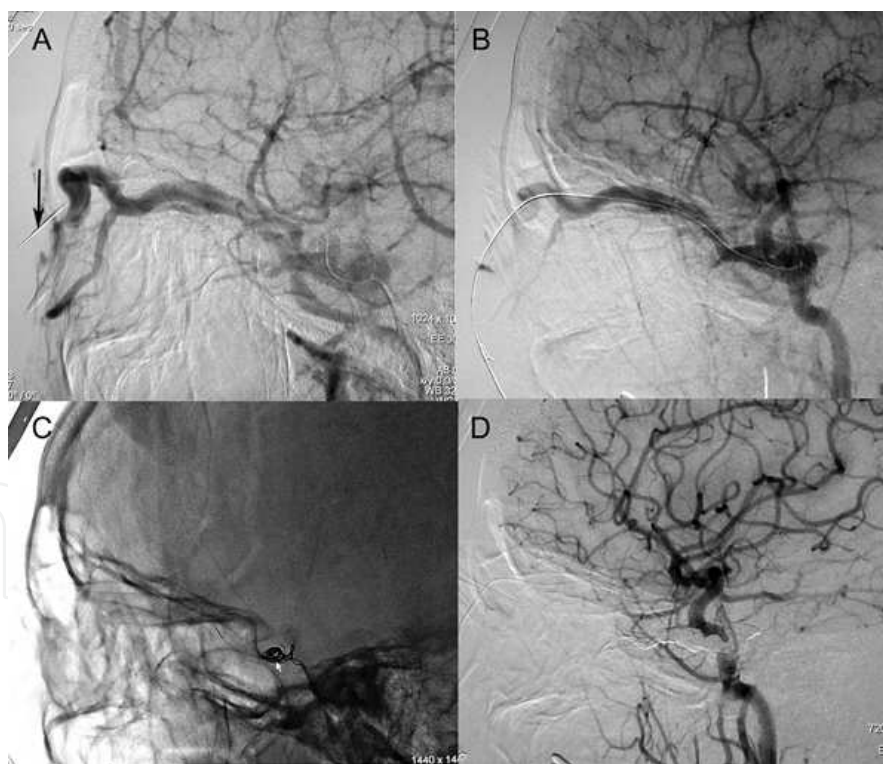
Right CCA angiogram, frontal projection (A), showing a DAVF involving the right CS fed by the left meningo-hypophyseal trunk and the right internal maxillary artery. Venous phase of the right CCA (B) demonstrated the venous drainage via the right IPS, the superficial temporal vein and the facial vein. Superselective angiography (C) showed the microcatheter in the right CS. Right CCA angiogram, frontal projection (D), showing the right CS completely packed. Skull X-ray film, frontal projection (E) showing the deposited Onyx in the right CS.
